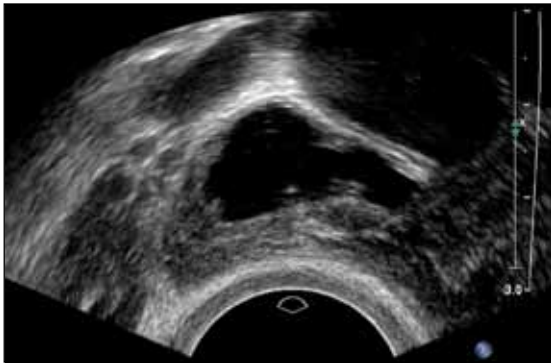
Hydrosalpinx on transvaginal ultrasound (cog wheel)
